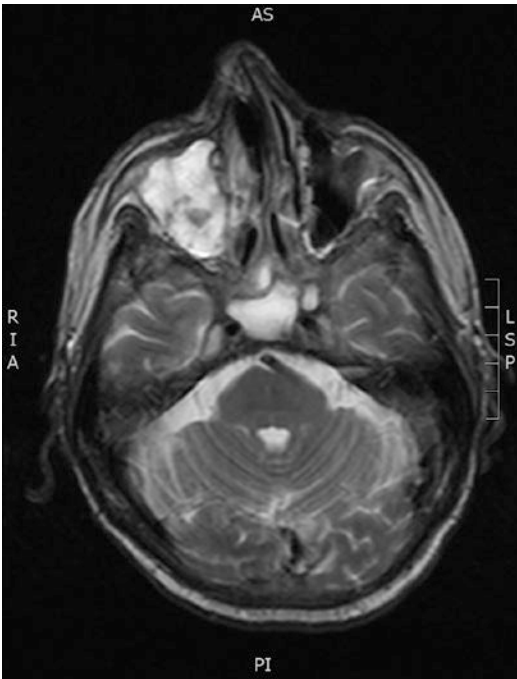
T2-weighted MRI
